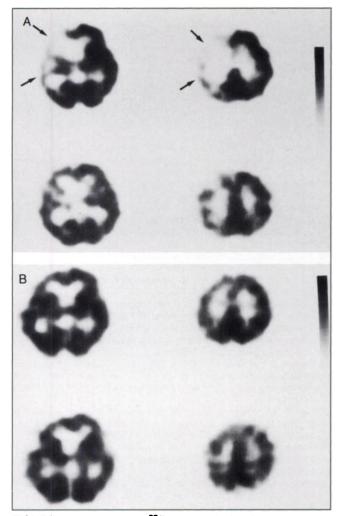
Consecutive <sup>99m</sup>Tc-HMPAO SPECT studies performed on a patient (a 63-yr-old male) with right ICA occlusion before (A) and after (B) external to internal cranial bypass surgery. Preoperative SPECT study (A) demonstrated mild hypoperfusion during normocapnia and poor response of rCBF to  $CO_2$  in the right MCA territory (arrows) when compared with the left. A postoperative follow-up SPECT study (B) demonstrated improvement in impaired  $CO_2$  reactivity in the right MCA territory. Upper row: brain perfusion images during hypercapnia; lower row: those during normocapnia.
